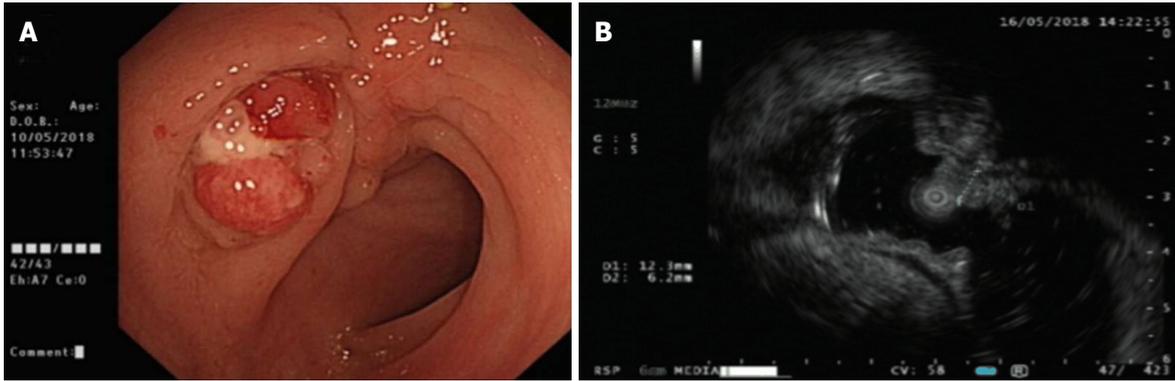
Endoscopic findings. A: Colonoscopy revealed a polypoid lesion in the sigmoid colon, which was hyperemic and oozed a pus-like substance; B: Endoscopic ultrasonography showed a mucosal lesion (1.23 cm × 0.62 cm) with a cavity-like structure below in sectional dimension.
